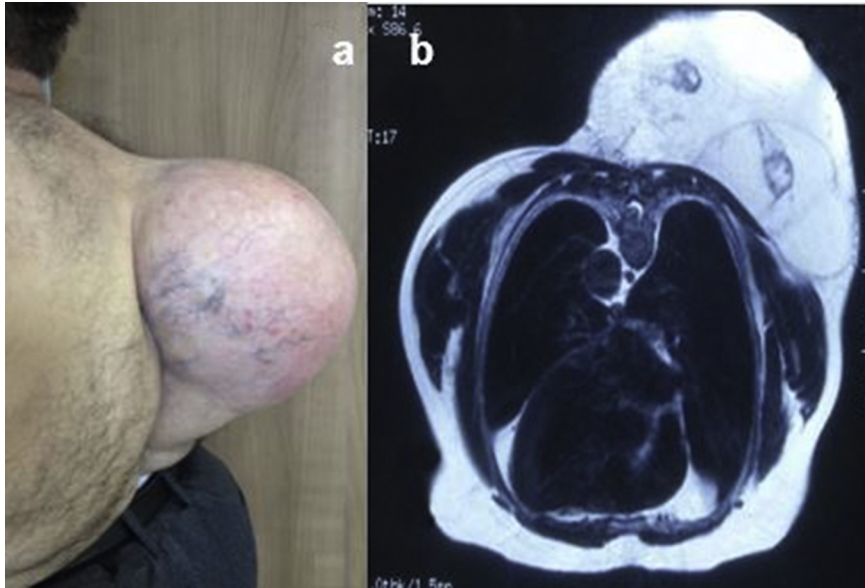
(a) Lateral view of the patient with a mobile mass localised on the mid-thoracic region preoperatively. (b) Mass on axial MRI images.
